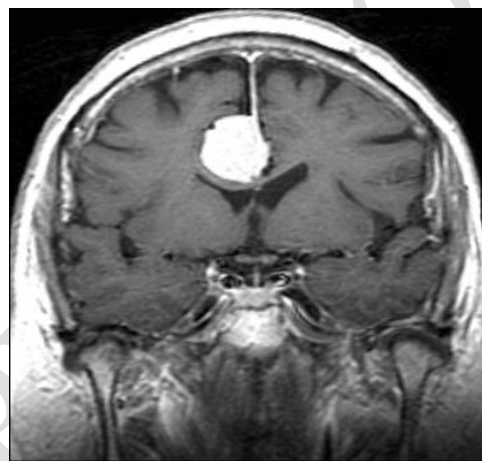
Coronal T1 post contrast MRI showing right sided Falcie meningioma
